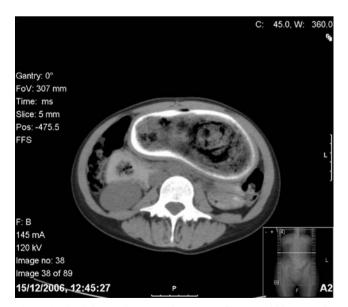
CT abdomen demonstrating extent of bezoar within stomach.
